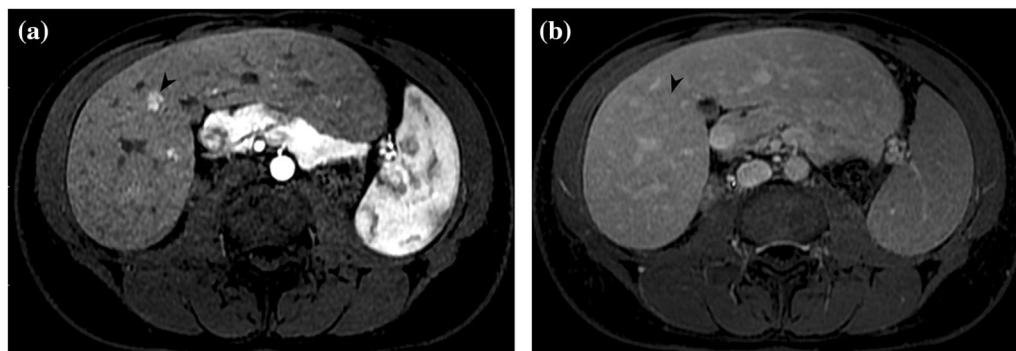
Axial postgadolinium MRI of abdomen a arterial phase demonstrating hyperenhancement, b portal venous phase showing lesion (black arrowhead) isoenhancing to rest of the liver parenchyma
